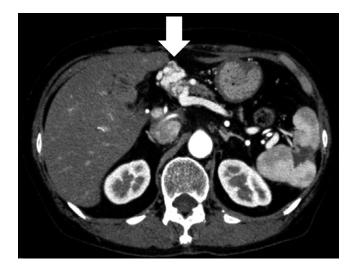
Preoperative contrast-enhanced computed tomography showing the varices of the elevated jejunum (arrow).
